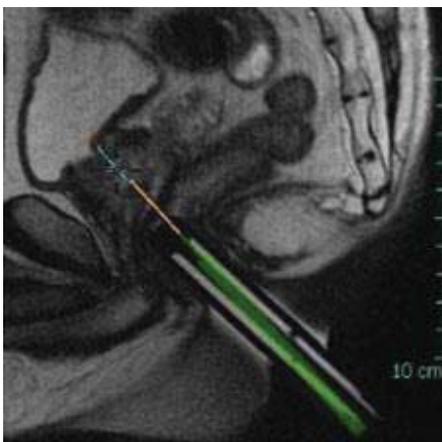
MRI guided biopsy
